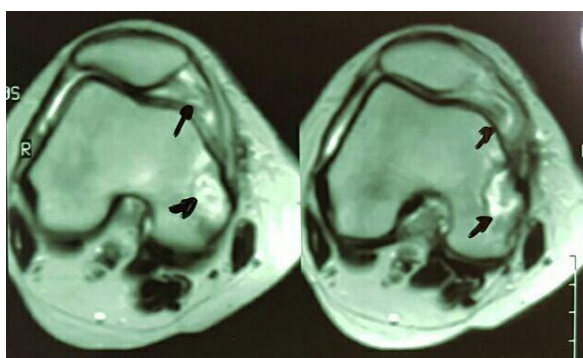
MRI image: a few small round shape lesions in the right popliteal region are mostly due to synovia hydatidosis
